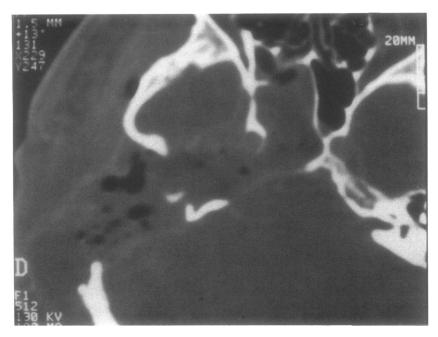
Infralabyrinthineapical cholesteatoma. Postoperative CT, axial section, shows the complete absence of any cholesteatoma recurrence. The temporal muscle has completely obliterated the homolateral sphenoid sinus.
